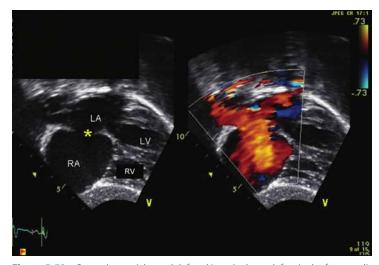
Secundum atrial septal defect. Note the large defect in the fossa ovalis area (*) on the subcostal view (*left*). Color Doppler (*right*) confirms a prominent left-to-right shunt (red flow). LA, left atrium; LV, left ventricle; RA, right atrium; RV, right ventricle.
